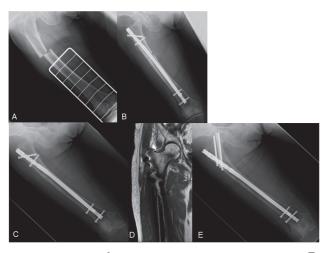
Case 2. A, Radiograph showing the right AFF; B, Postoperative radiograph showing the intramedullary nail (IMN) fixation; C, The non-displaced femoral neck fracture; D, Low signal intensity on T1-weighted images showing bone marrow edema around the femoral neck; E, Exchange of the intramedullary nails and screw fixation.
